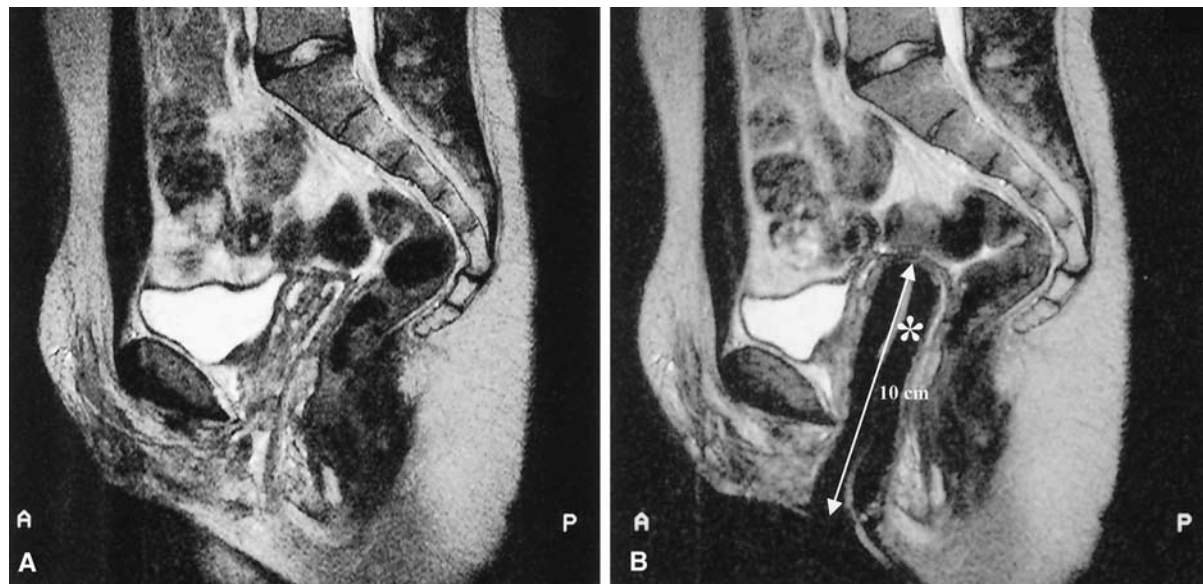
Sagittal turbo spin-echo T2-weighted images acquired without (A) and with (B) an inflatable silicon tutor in the neovagina (*).
